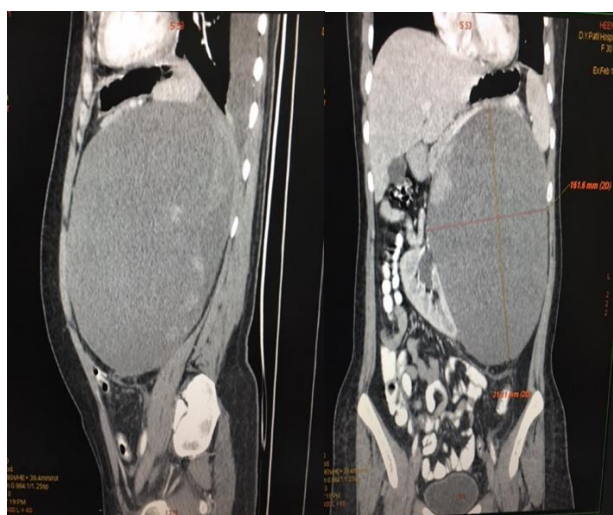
Abdominal computed tomography showed dimensions of large well-defined lesion.
